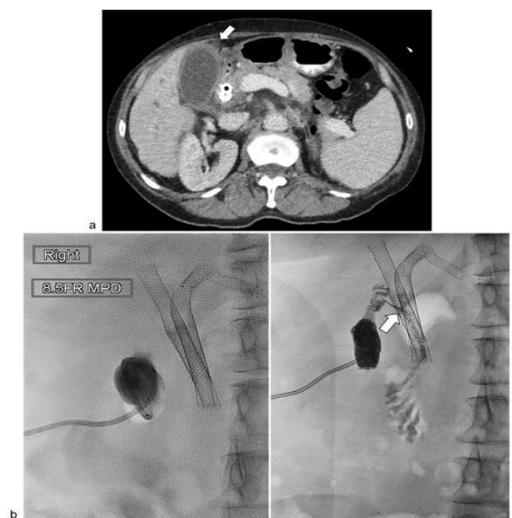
(a) A 66-year-old woman with Bismuth IV cholangiocarcinoma treated with bilateral bare metal stents in a Y-configuration presents with right upper quadrant pain, fever, and leukocytosis. CT with contrast demonstrates gallbladder wall thickening and surrounding fat stranding (arrow) suspicious for acute cholecystitis. (b) Cholecystostomy catheter was placed. Contrast injection shows no free passage of contrast into the cystic duct. (c) Contrast injection after 1 month shows free passage of contrast from the gallbladder to the small bowel (arrow). The catheter was eventually removed with no recurrence of cholecystitis (9).
